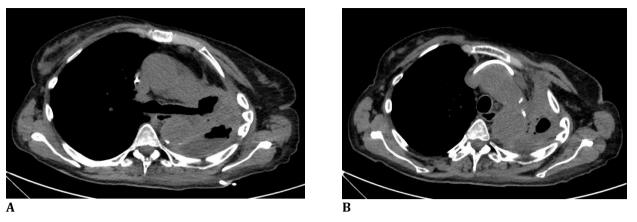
Axial cuts (A=upper, B=lower), CT scan (27th of September 2022)
